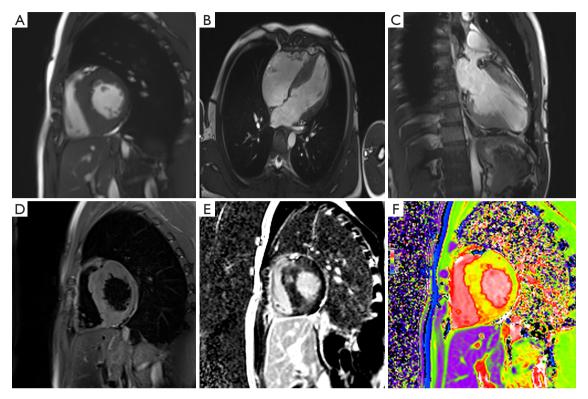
MR scanning sequences in patients with hypertrophic cardiomyopathy: (A) cine short-axis; (B) cine long-axis 4-chambered; (C) cine long-axis 2-chambered; (D) T2WI; (E) late gadolinium enhancement; (F) T1 mapping. MR, magnetic resonance; T2WI, T2-weighted imaging.
